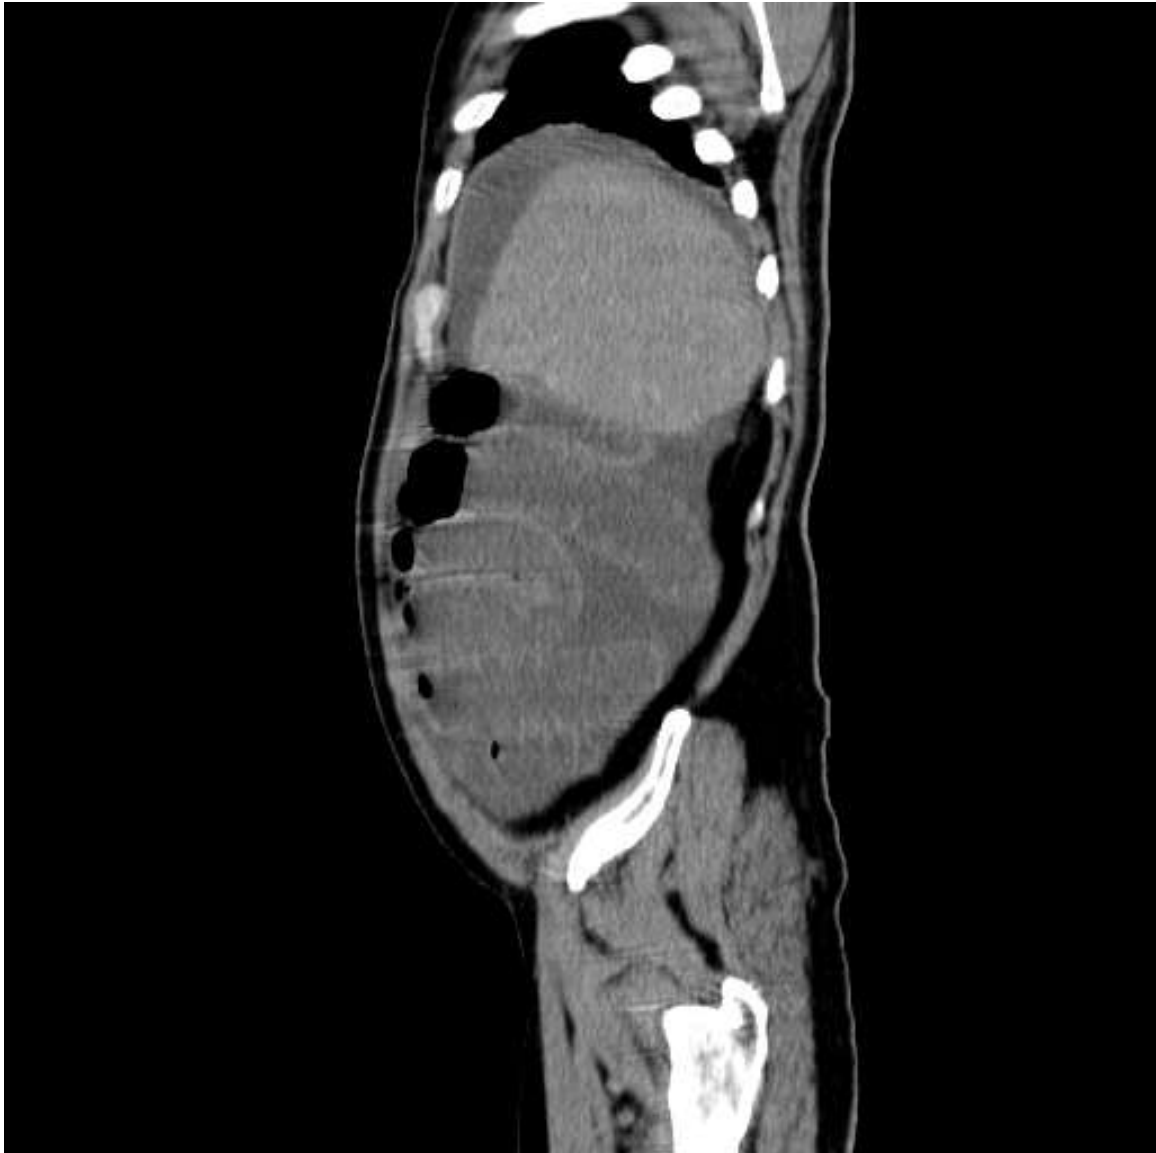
plain CT Sagittal. Ischaemic dilated small bowel loops and ascites.
